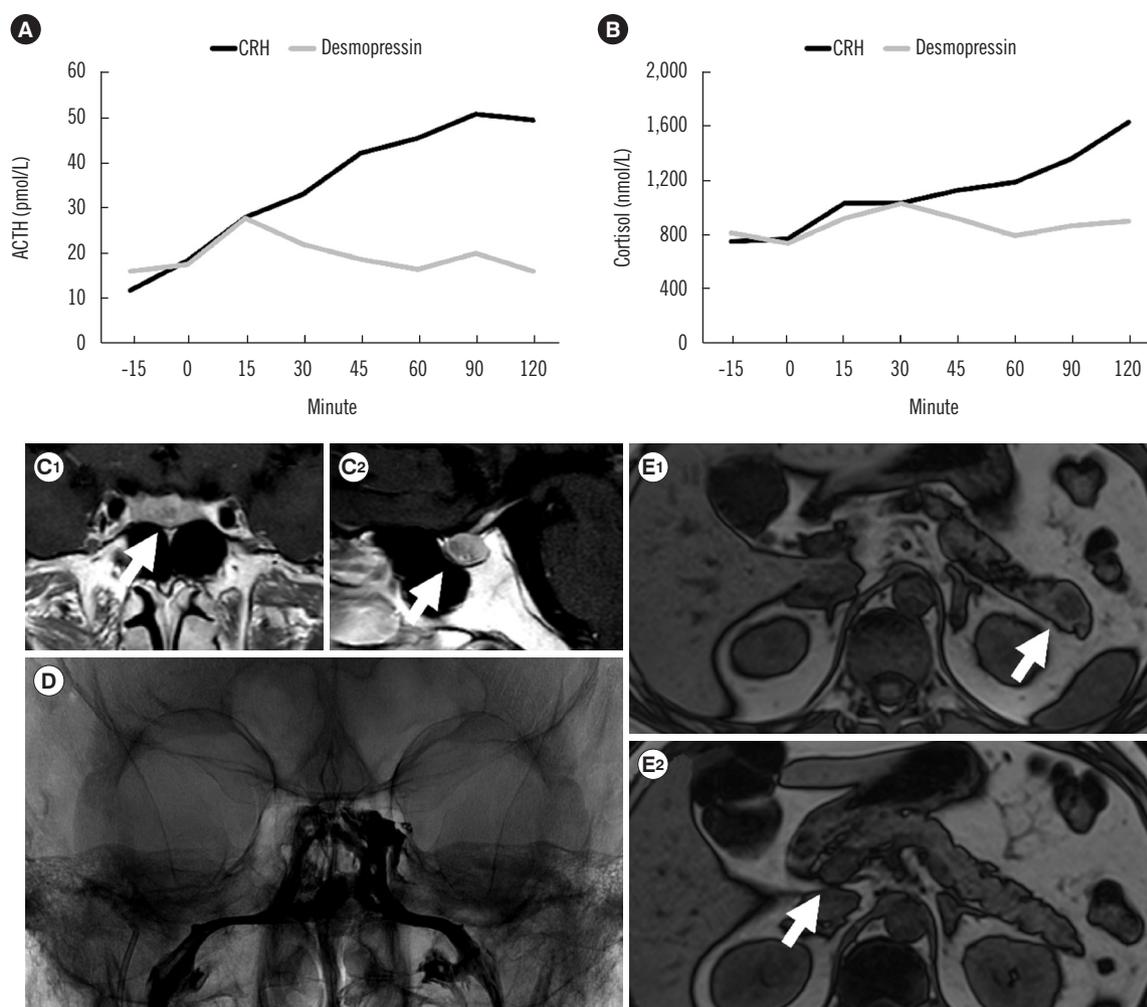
Dynamic tests and radiological features of the case presented in the text. (A) ACTH and (B) cortisol response to the CRH test (black) and desmopressin test (gray). (C–E) Magnetic resonance images showing the hypo-intense anterior-medial pituitary adenoma (white arrows) in the coronal (C1) and sagittal (C2) planes; enhanced image during bilateral inferior petrosal sinus sampling (D); and the pancreatic tail (E1) and head (E2) nodules in the axial plane (white arrows).
